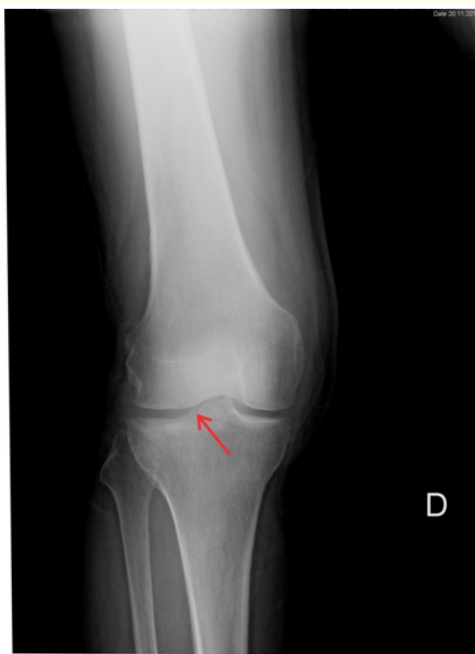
X-ray imaging of a lateral tibial plateau fracture (overlooked fracture).
